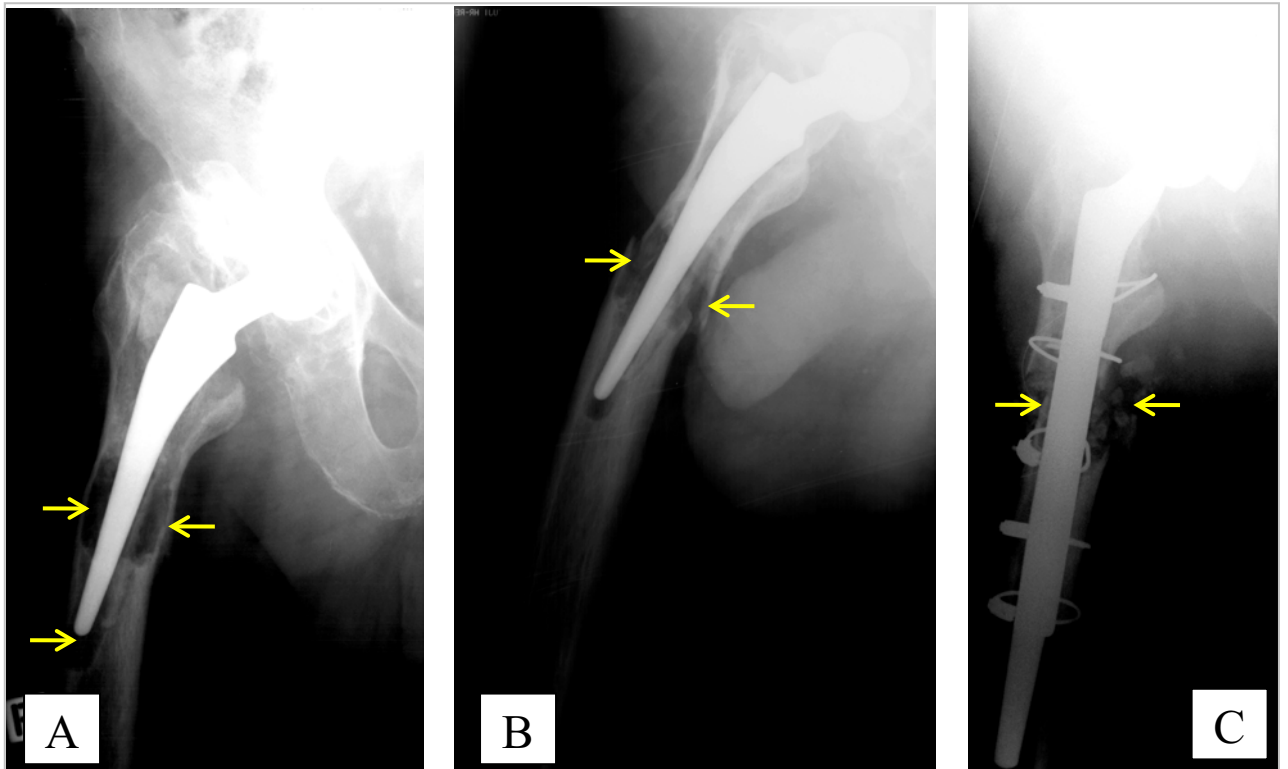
Plain radiography of right hip joint showing fracture associated with femoral periprosthetic osteolysis.
